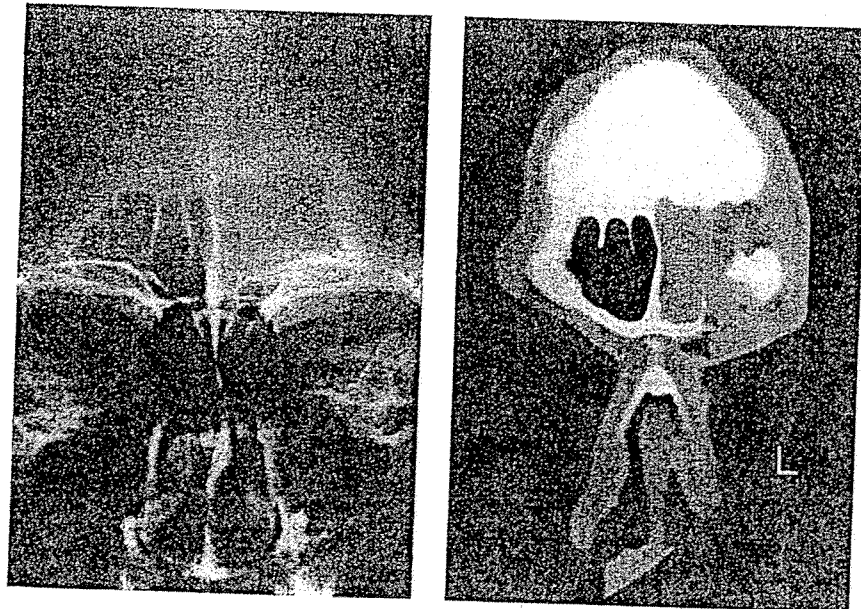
Sinus X-ray (left) and magnetic resonance imagery study (right) of an ARC patient with a history of sinusitis who developed a squamous cell carcinoma of the left maxillary sinus. As the AIDS epidemic matures, physicians should be alert for unusual tumors developing in HIV-infected individuals.
